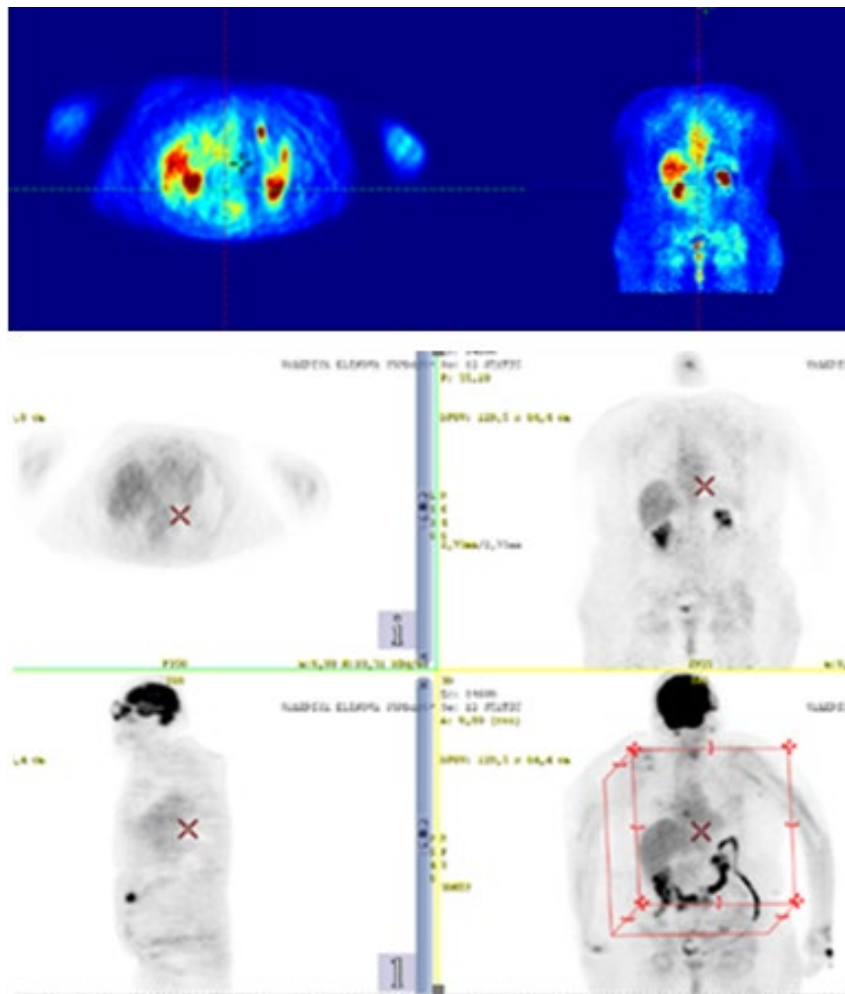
PET/CT/May 2023 after 6 months of the RT completion without metabolic activity in the para-aortic lymph nodes
